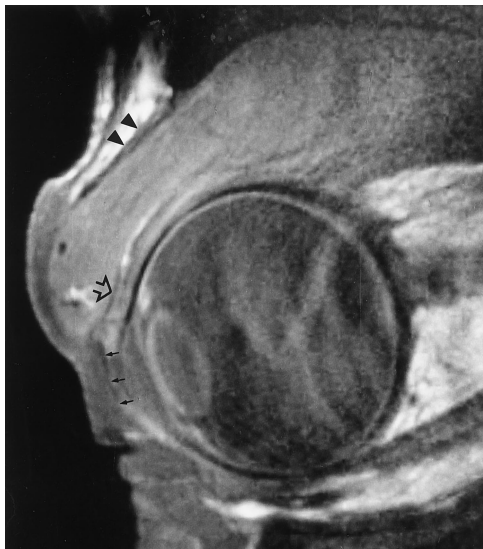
T1-weighted sagittal MR image (600/20/2) of the left orbit of a 48-year-old patient with non-Hodgkin lymphoma. The large intraorbital mass, occupying the postseptal space, curves the palpebral part of the orbicularis oculi muscle as well as the tarsus (*small arrows*) and stretches the septum orbitale (*arrowheads*). The thickened appearance of the septum is probably due to closely adjoining fibers of the levator aponeurosis. *Open arrow* indicates levator tarsi superior muscle.
